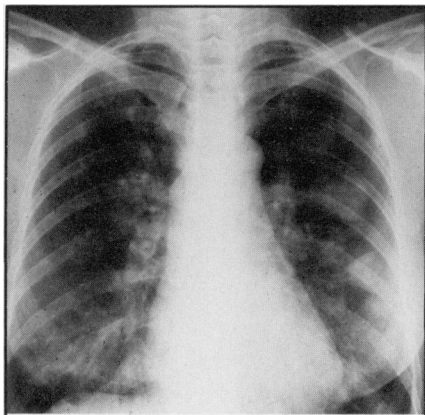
A 1975 chest radiograph showing bilateral, ill-defined, pulmonary nodules.
